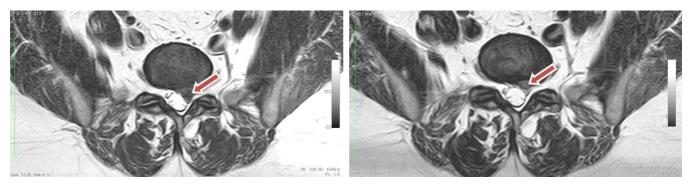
AXIAL T2WI MRI OF A PATIENT BEFORE (A) AND AFTER (B) TREATMENT. THE MORPHOLOGY GRADING OF THE DISC CHANGED FROM GRADE 4 (SEQUESTRATION) TO GRADE 2 (PROLAPSE).
